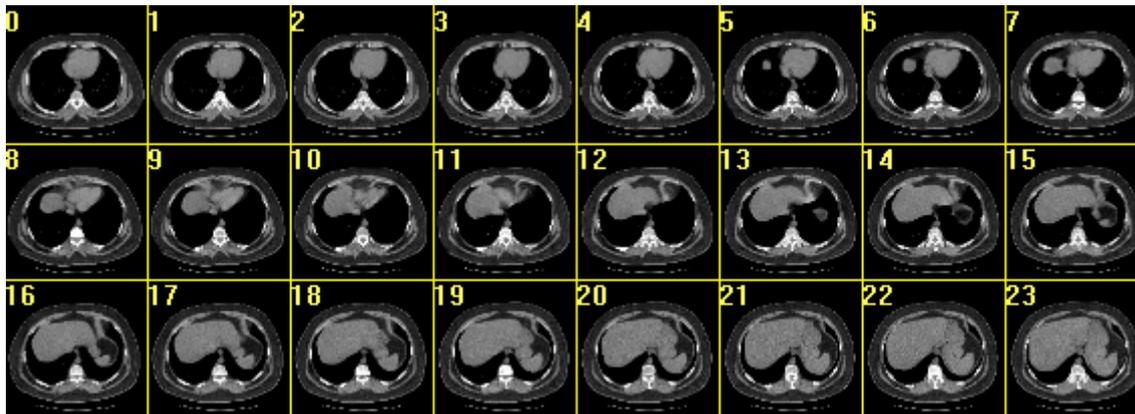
The first 23 CT slices of a total number of 355.
